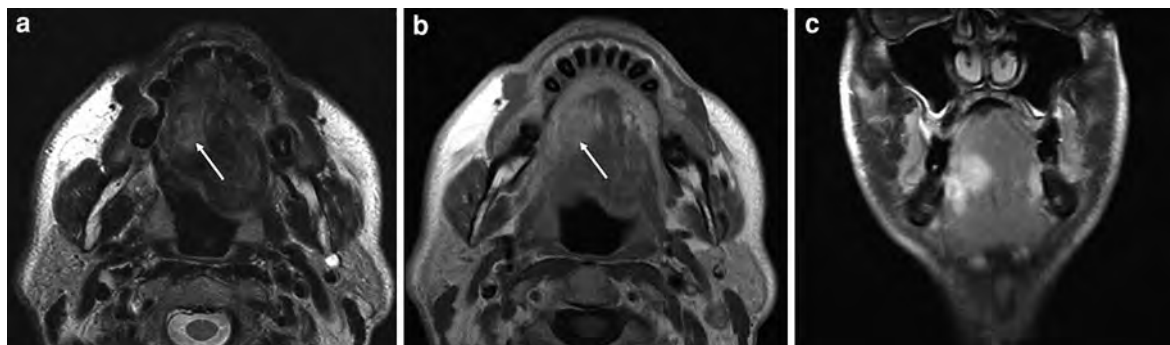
MRI of a 56-year-old man with a local recurrence after resection of a squamous cell carcinoma of the tongue and respective asymmetric changes of the anatomy. The T2-weighted image shows a small hyperintense lesion (*arrow*)
